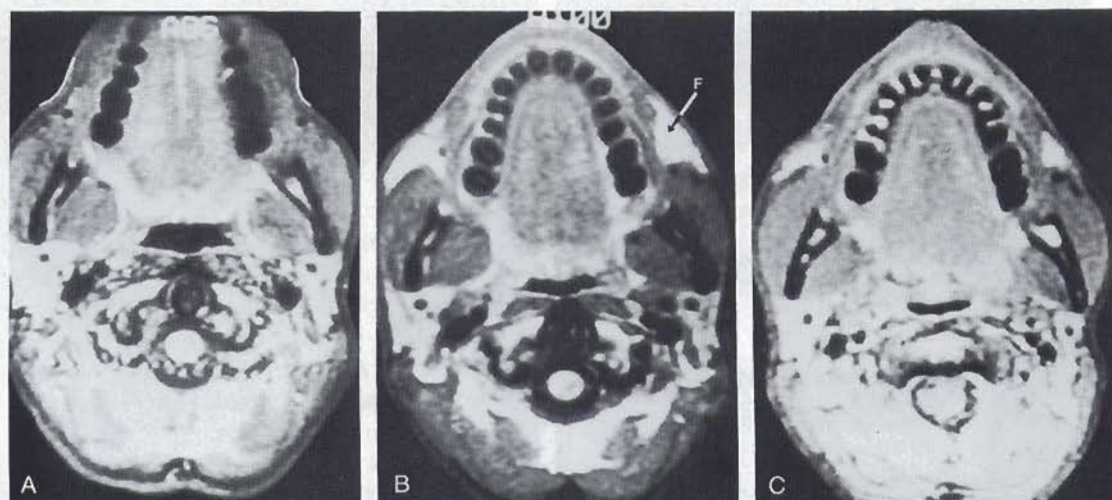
A, Case 5. MR image of a patient with congenital facial lipodystrophy. B, MR imaging immediately after fat injection. C, MR imaging of same patient 6 months after fat injection procedure. (From Davis, PL, Narayanan K, Liang M, et al: Magnetic resonance imaging of facial lipodystrophy. *Am J Cosmetic Surg* 6:249-251, 1989; with permission.).
